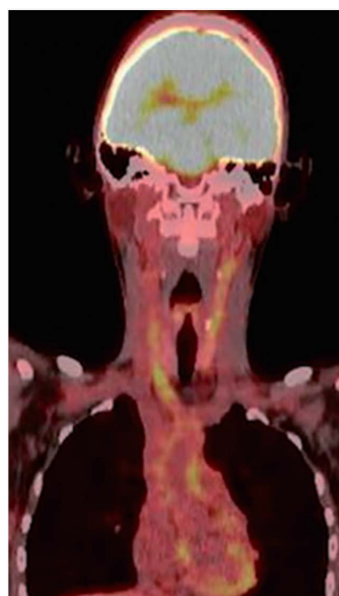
Initial FDG-PET/CT at first diagnostic evaluation.
